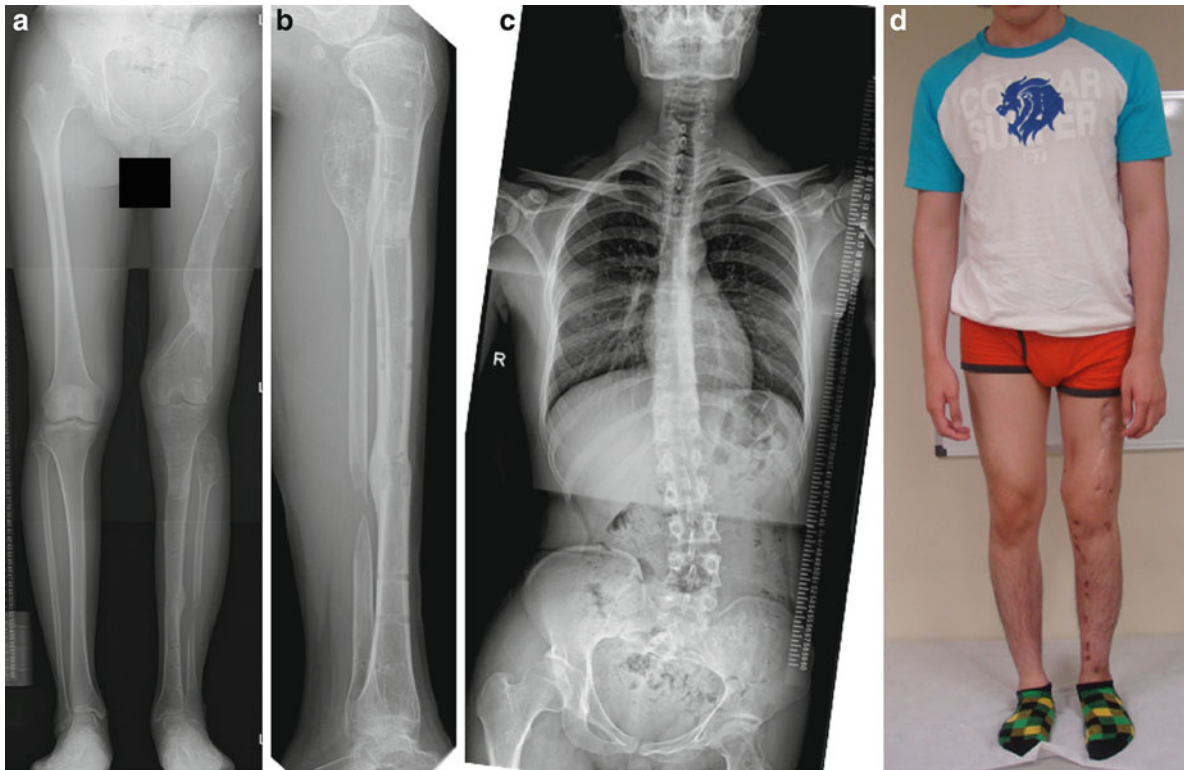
(a–d) Radiographs after tibial lengthening (leg length discrepancy of 30 mm was left to adjust the rigid scoliosis)
